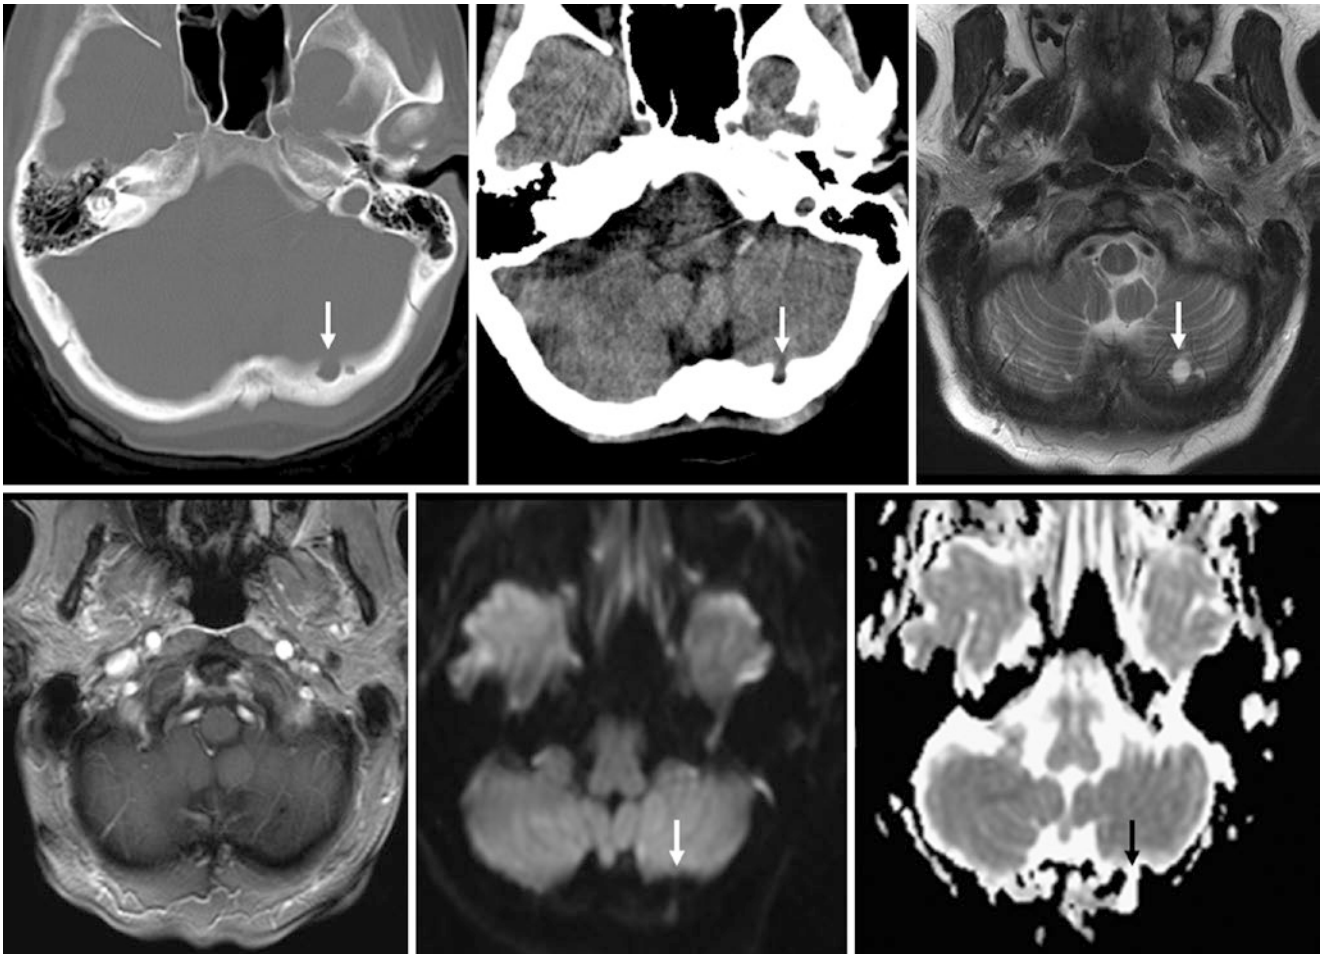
A 65 year old with a small left occipital pacchionian granulation that is lobulated on NECT (*top left and middle*) and bright on T2WI MRI (*top right*). It lacks enhancement on T1WI (*bottom left*) and is without reduced diffusion on DWI (*bottom middle*) or ADC map (*bottom right*)
